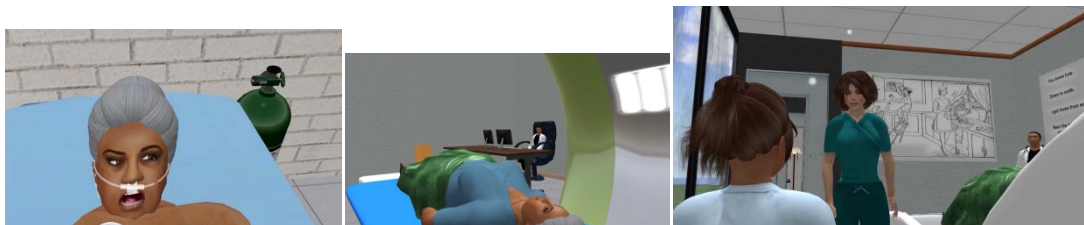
Avatar behaviors (from left to right: open mouth; go through CT Scanning, take NIHSS exam)
